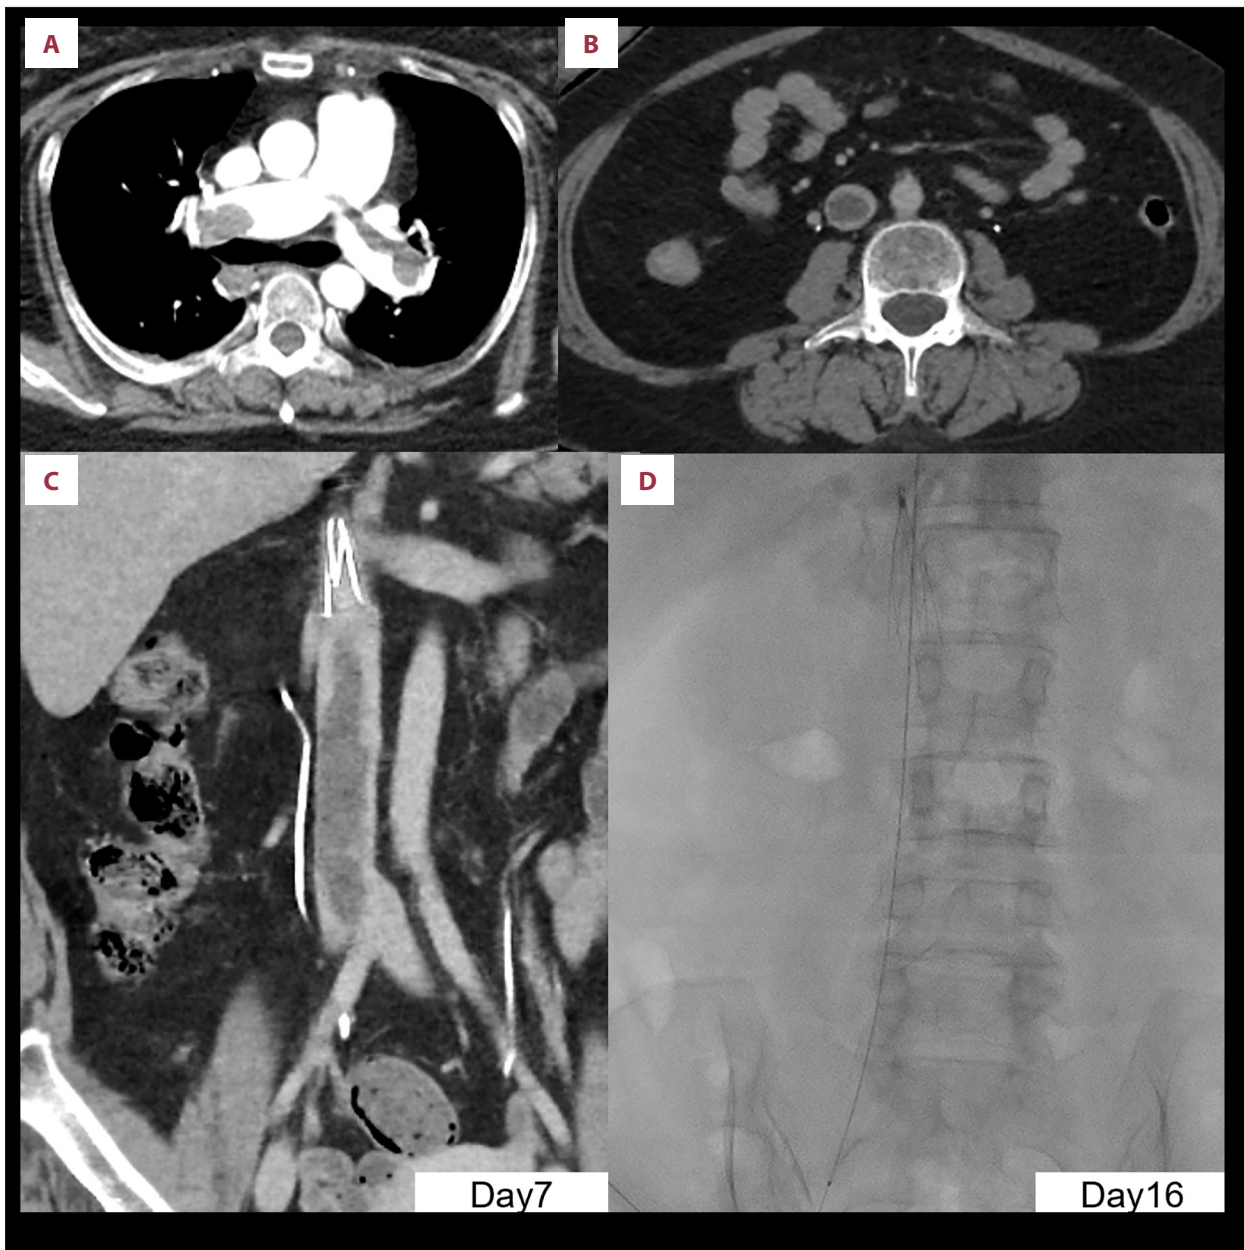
Contrast-enhanced CT findings on admission and at follow-up, and imaging during catheter-directed thrombolysis. On contrast-enhanced CT at admission, thrombi were identified in the bilateral pulmonary arteries (A), along with a massive thrombus in the IVC (B). One week after IVC filter placement and initiation of anticoagulation, the IVC thrombus remained unchanged (C). A pulse-spray catheter (Fountain infusion catheter) was subsequently inserted via the right internal jugular vein, with the side holes positioned across the thrombotic segment of the IVC (D). CT, computed tomography; IVC, inferior vena cava.
